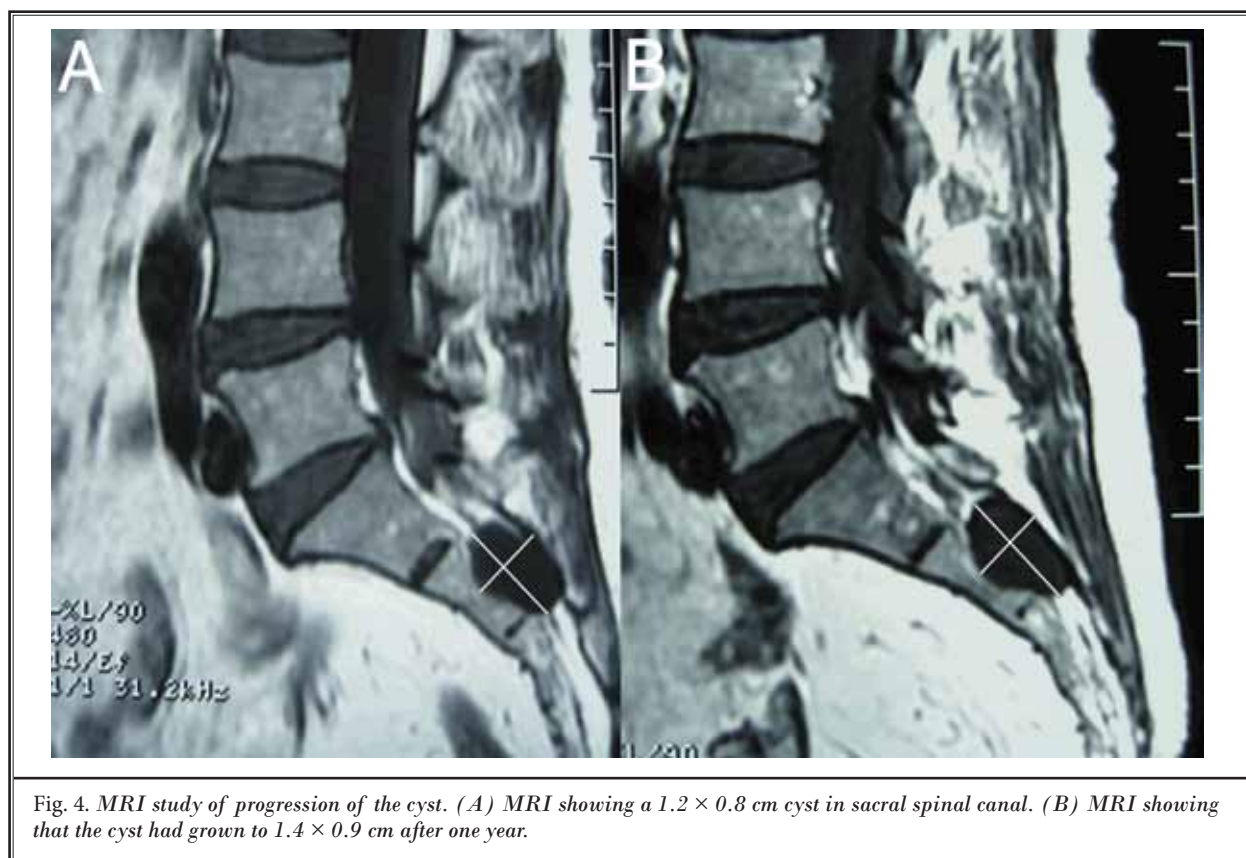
MRI study of progression of the cyst. (A) MRI showing a 1.2×0.8 cm cyst in sacral spinal canal. (B) MRI showing that the cyst had grown to 1.4×0.9 cm after one year.
